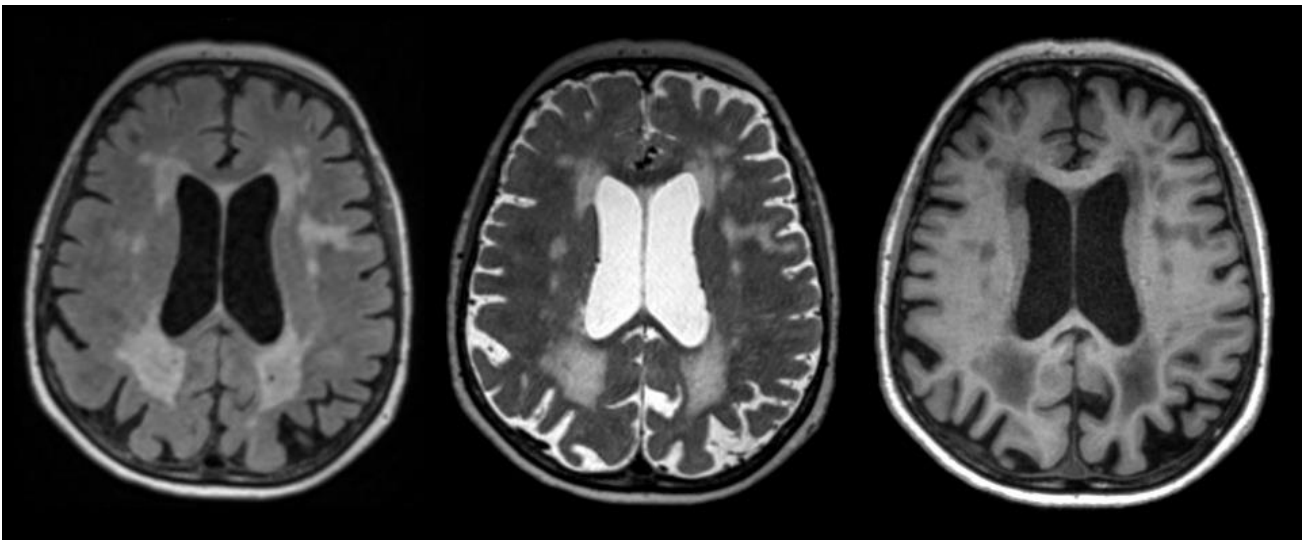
White matter hyperintensities of presumed vascular origin on high spatial resolution magnetic resonance imaging. Confluent white matter hyperintensities (WMH) in a 70-year-old person. WMH appear hyperintense on fluid-attenuated inversion recovery (FLAIR) (left) and T₂-weighted images (middle), and hypointense on T₁-weighted images (right).
